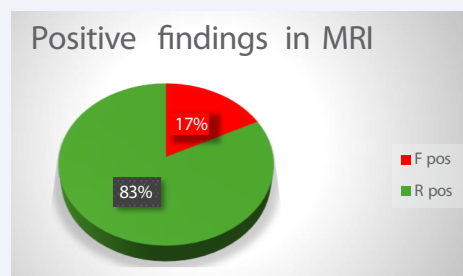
False-positive and true-positive findings in HR breast MRI.
